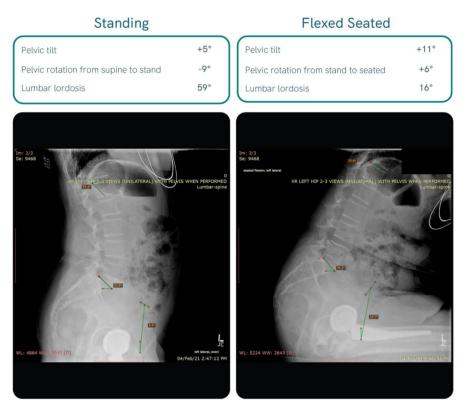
Measurements made on functional standing (left) and flex-seated (right) radiographs.
